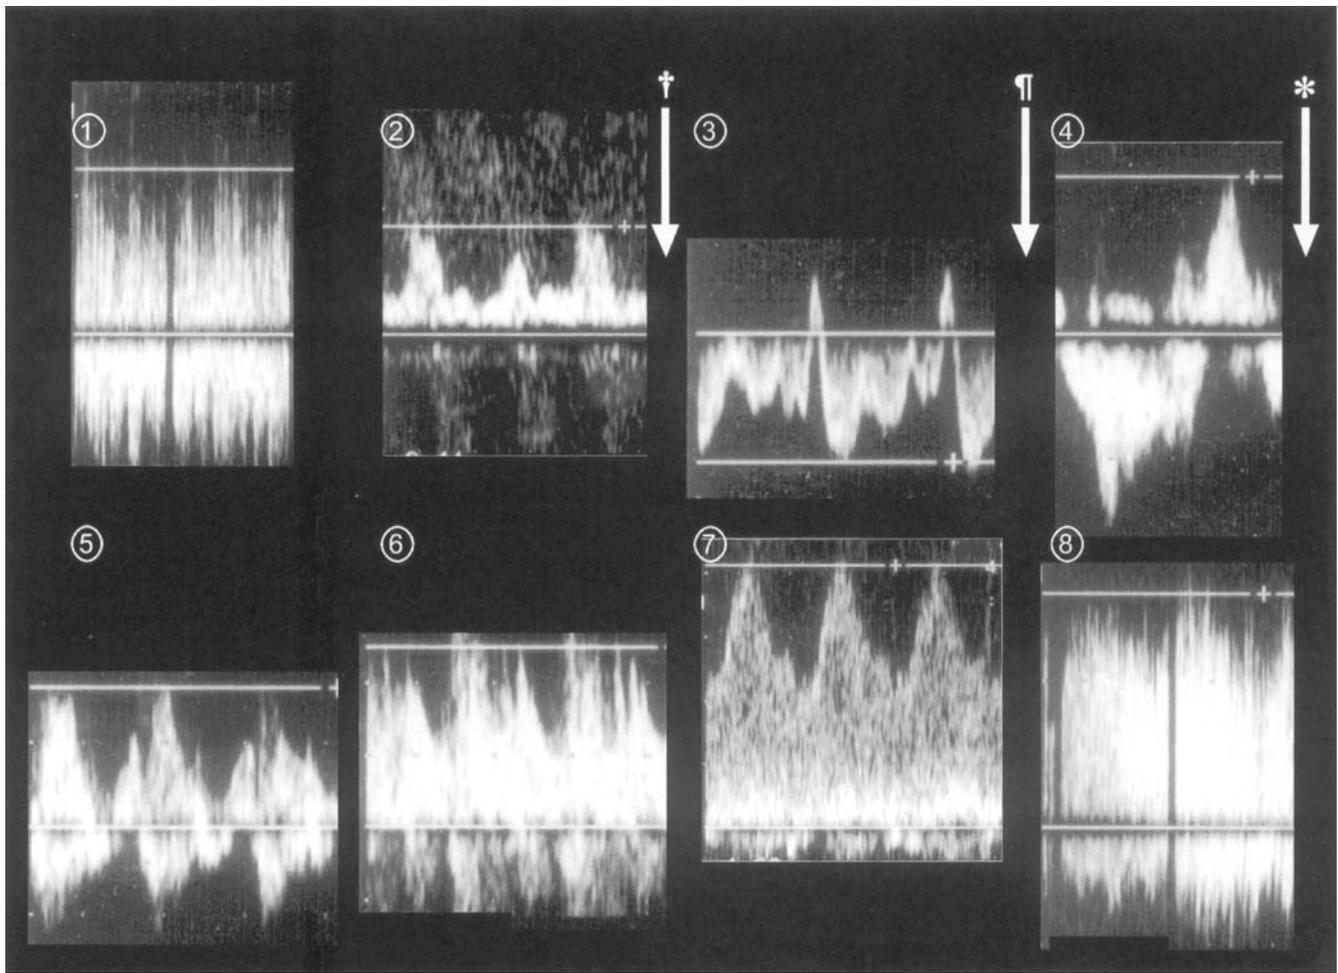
Serial changes in waveform and peak flow velocity of the graft portal vein (umbilical portion) with Doppler US.
